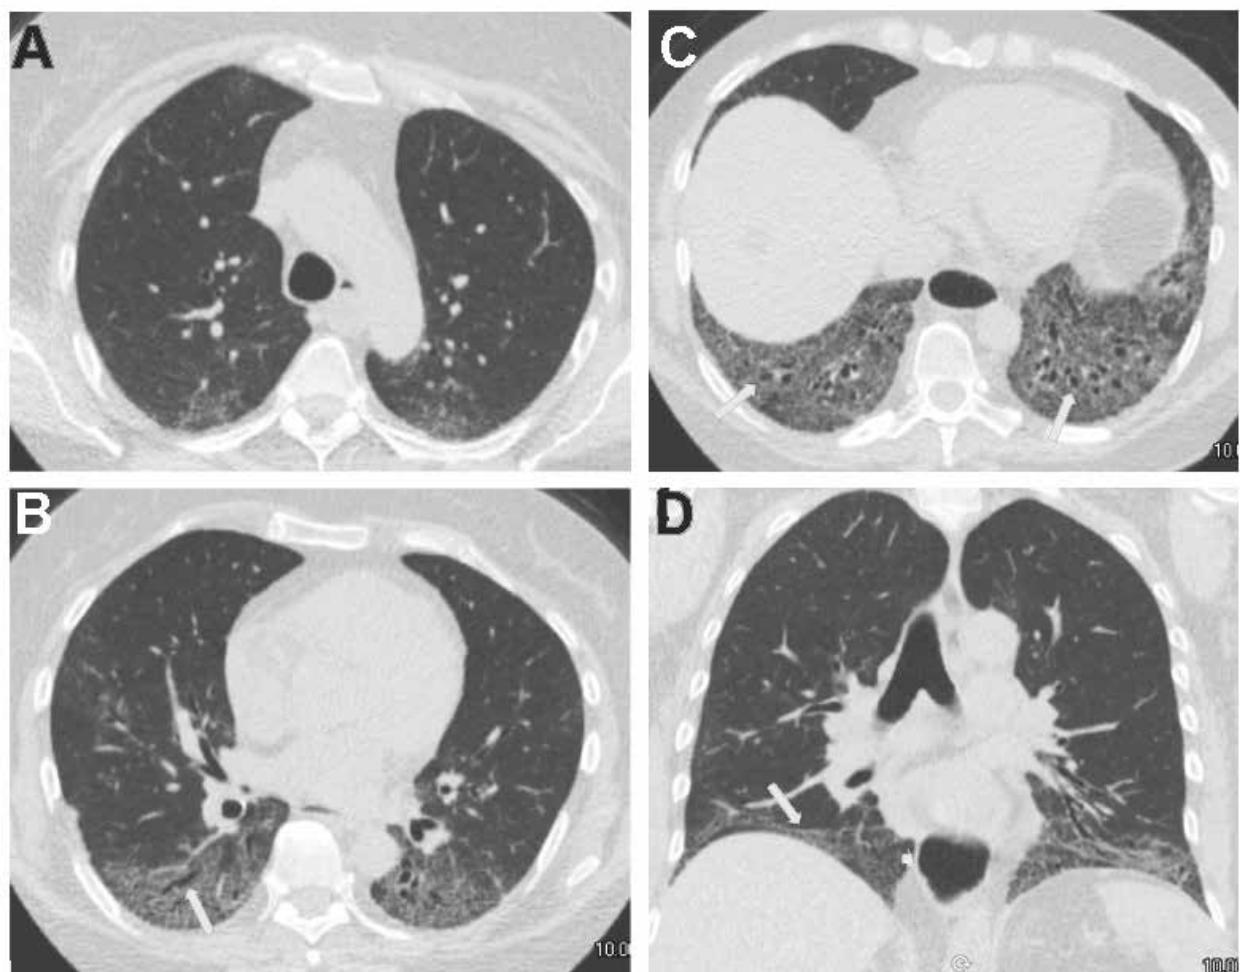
HRCT scans at follow up from a patient with SSc-ILD. Axial image at the level of the aortic arch (A), axial image at the left inferior pulmonary vein ostium (B), axial image just above the hemidiaphragms (C), and coronal image (D). The ground glass densities in the upper lobes in A have worsened modestly. Imaging through the mid and lower lungs in B and C shows clear progression of the basilar predominant ground glass density and reticulation. Traction bronchiectasis/bronchiolectasis has substantially worsened (arrows in C), compatible with fibrotic NSIP. Note the subpleural sparing is still evident posteriorly in B and C. Coronal image shows that basilar predominant ground glass opacities, reticulation, and traction bronchiectasis have worsened. The lower lobe volume loss has clearly progressed with marked downward displacement of the right major fissure (arrow in D). Note the dilated esophagus (arrowhead in D) typical of SSc.
